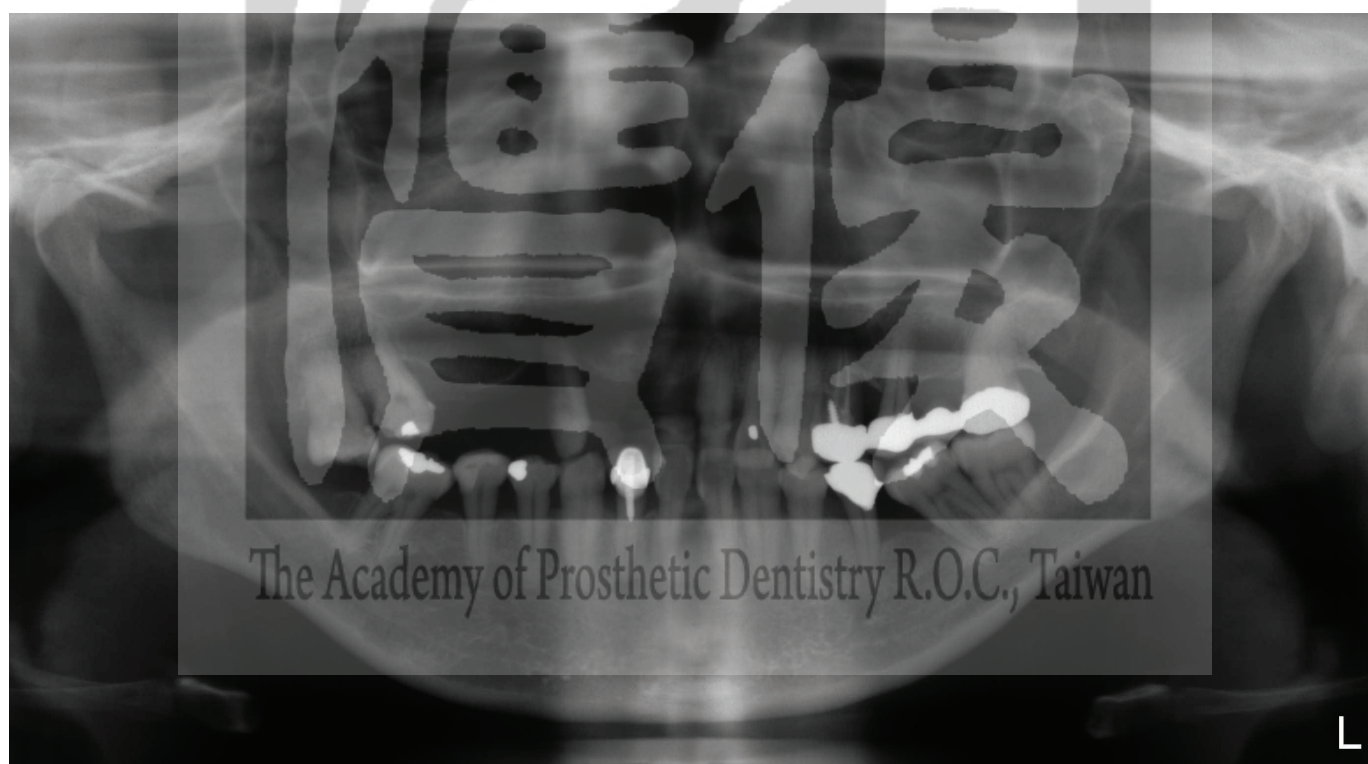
The initial panoramic x-ray showed 13,17,21 advanced bone loss
